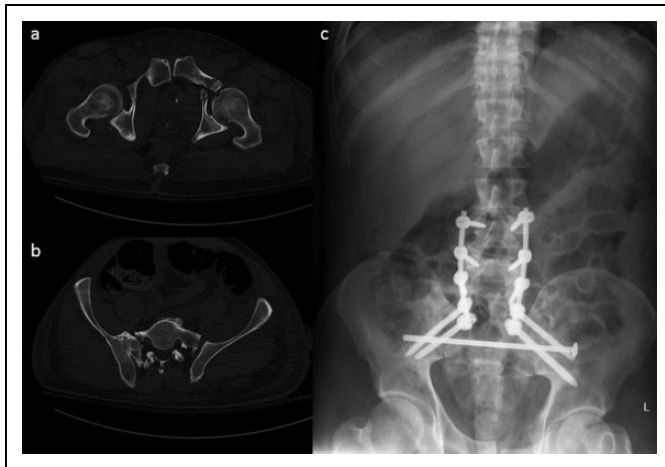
Sacral fracture with M3 modifier. (a) Axial CT shows anterior pelvic ring injury in the setting of (b) bilateral sacral ala fractures with left SI joint widening. (c) Plain films show lumbopelvic and sacral fixation without need (in this case) for anterior pelvic fixation.
